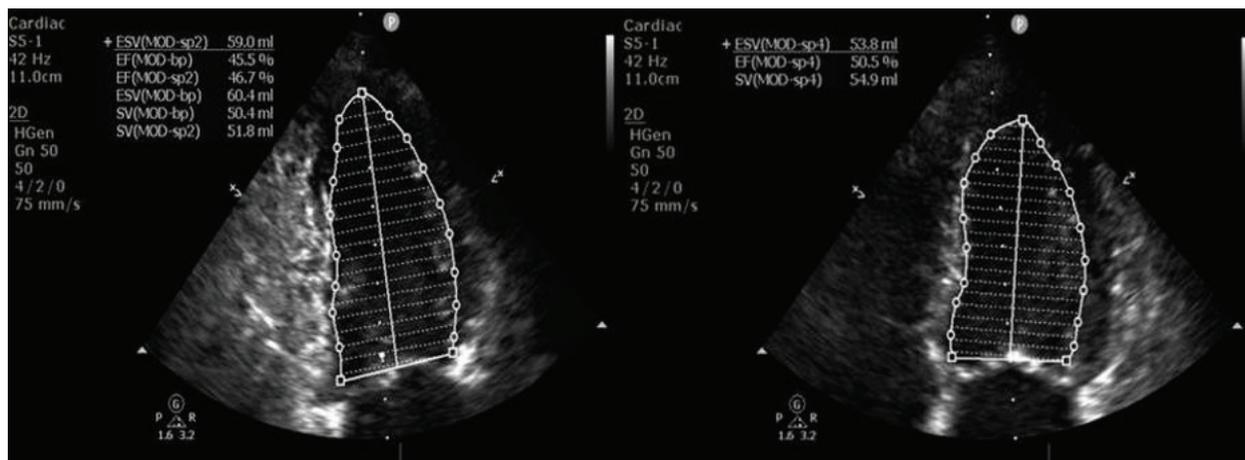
A 56-year-old male patient with atrial fibrillation was diagnosed with acute myeloid leukemia (AML) in August 2019 and treated with idarubicin at 12 mg/m²/d for 3 days and aracytin at 200 mg/m² for 7 days, achieving complete remission. Seven months after the diagnosis of AML, he suffered a left hemispheric stroke, due to atrial fibrillation. Transthoracic echocardiographic study showed mild-moderate systolic left ventricle dysfunction (ejection fraction of 45-50%) with hypokinesia in the basal inferior intraventricular septum and middle inferior and anterior walls.
